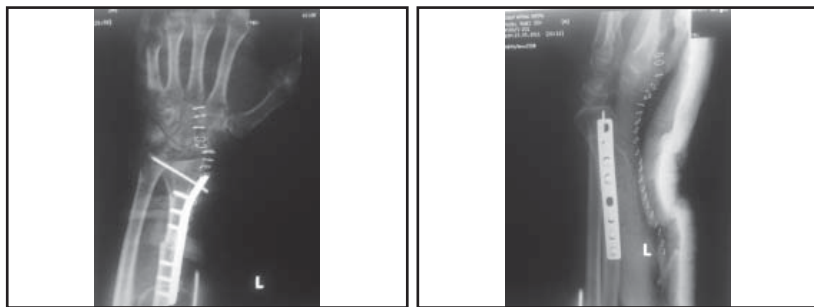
The post-operative x-ray of the same patient showing dynamic plate in position with K-wire
